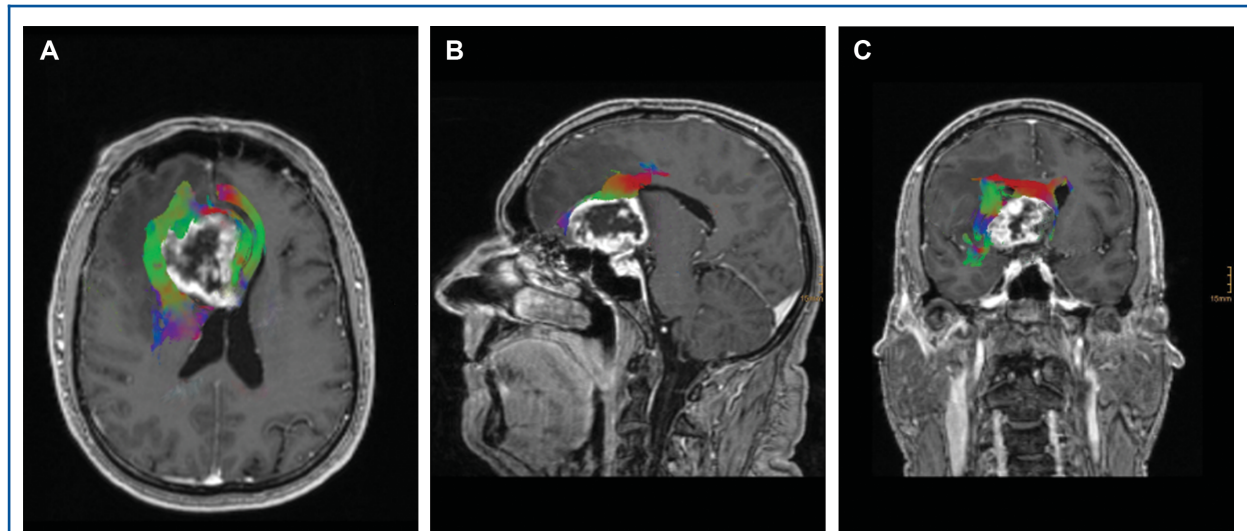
Diffusion tensor imaging of an OFC glioma on a 3-Tesla MRI. Postprocessing via syngo, via software package (Siemens). From left to right: A, transversal, B, sagittal, and C, coronal view. Intact lateral fibers including the external capsule and frontopontine fibers of the internal capsule (green A and blue C). Note the displaced but intact corpus callosum (red) and its frontal extension of the forcs minor limiting the superior extension of the tumor B.
